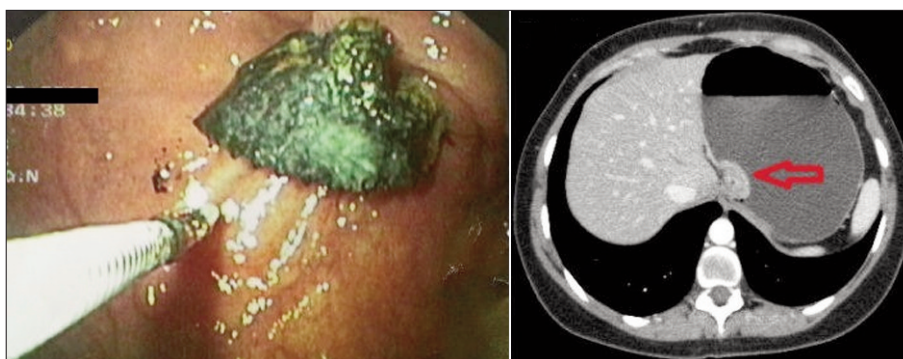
A, Gastroscopy showed partial migration of the polypropylene mesh into the wall of gastric fundus. B, Abdominal CT scan documented a hyperdense foreign body eroding the gastric wall (red arrow).
